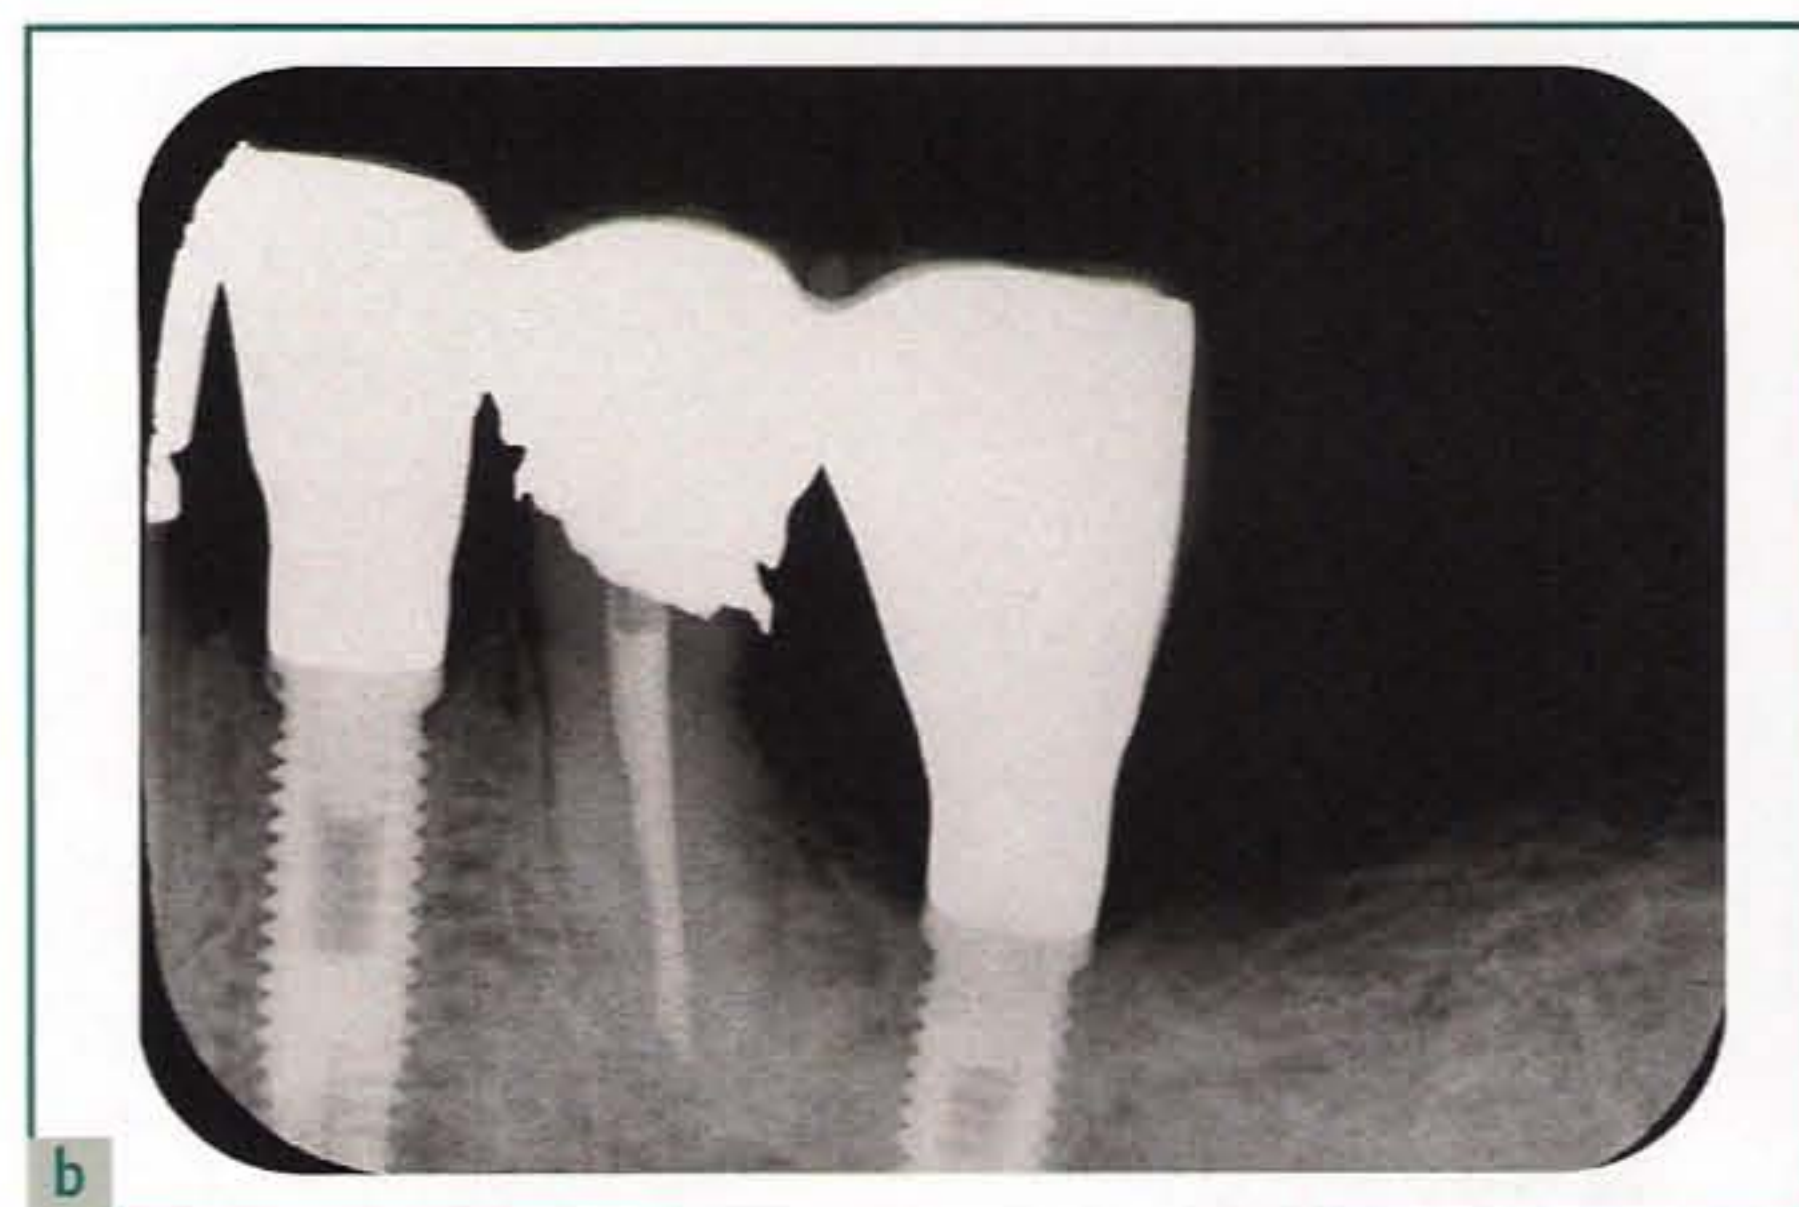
Intrusion of a natural abutment in a telescopic prosthesis with mixed support. Radiographs taken (a) at the placement of the prosthesis and (b) after 6 months. (Courtesy of Dr G. Cho, Los Angeles.)
